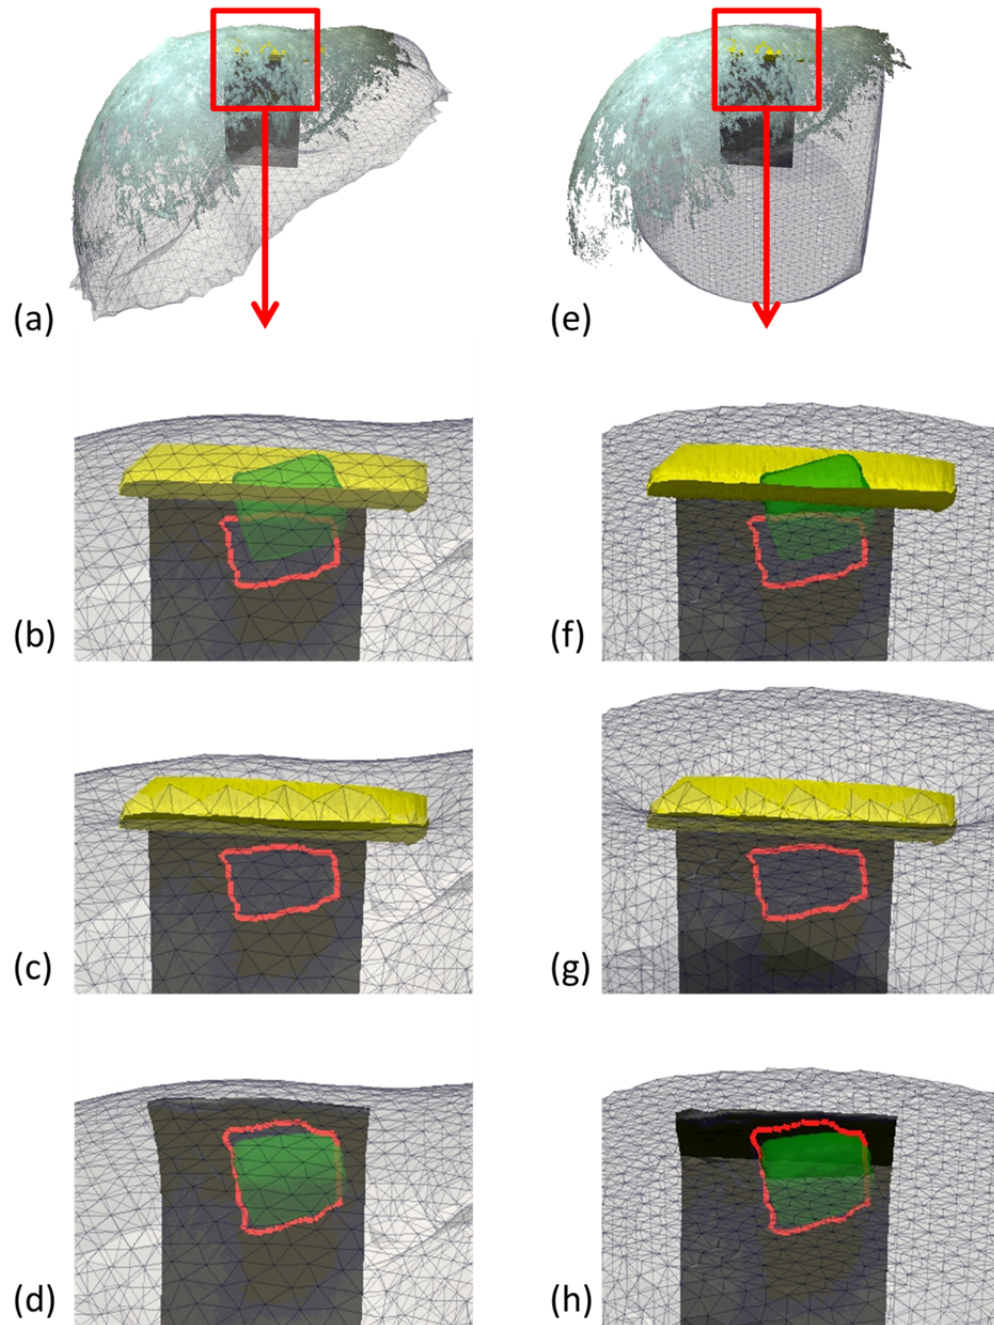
Example of the patient specific-model correction (a-d) and generic model correction (e-h) applied to a B-mode image slice. (a) and (e) show the co-registered LRS point cloud on the respective mesh, (b) and (f) show the tracked probe surface and the misalignment between the ultrasound tumor border with the CT tumor, (c) and (g) show the deformed mesh after creation of boundary conditions, and (d) and (h) show the undeformed mesh and corrected ultrasound image.
